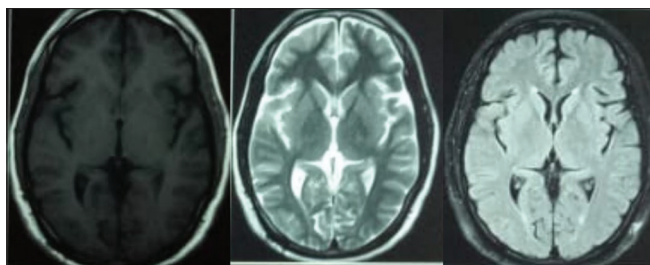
Axial MRI brain of the patient revealing normal findings
